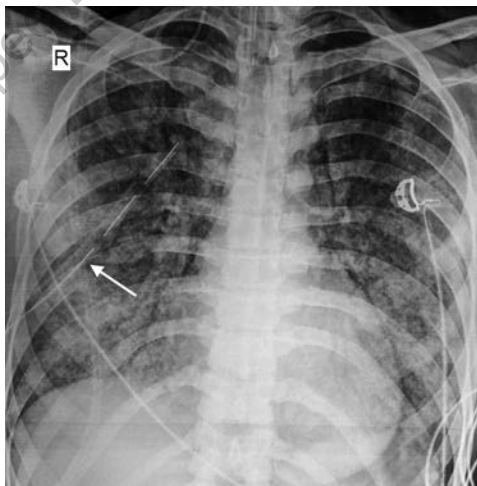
Chest radiograph showing an intercostal tube placed in the right pleural cavity. Note the radiopaque line (arrow) on the chest tube with side drainage holes visualized as defects in this line. Also note the fully expanded lung
